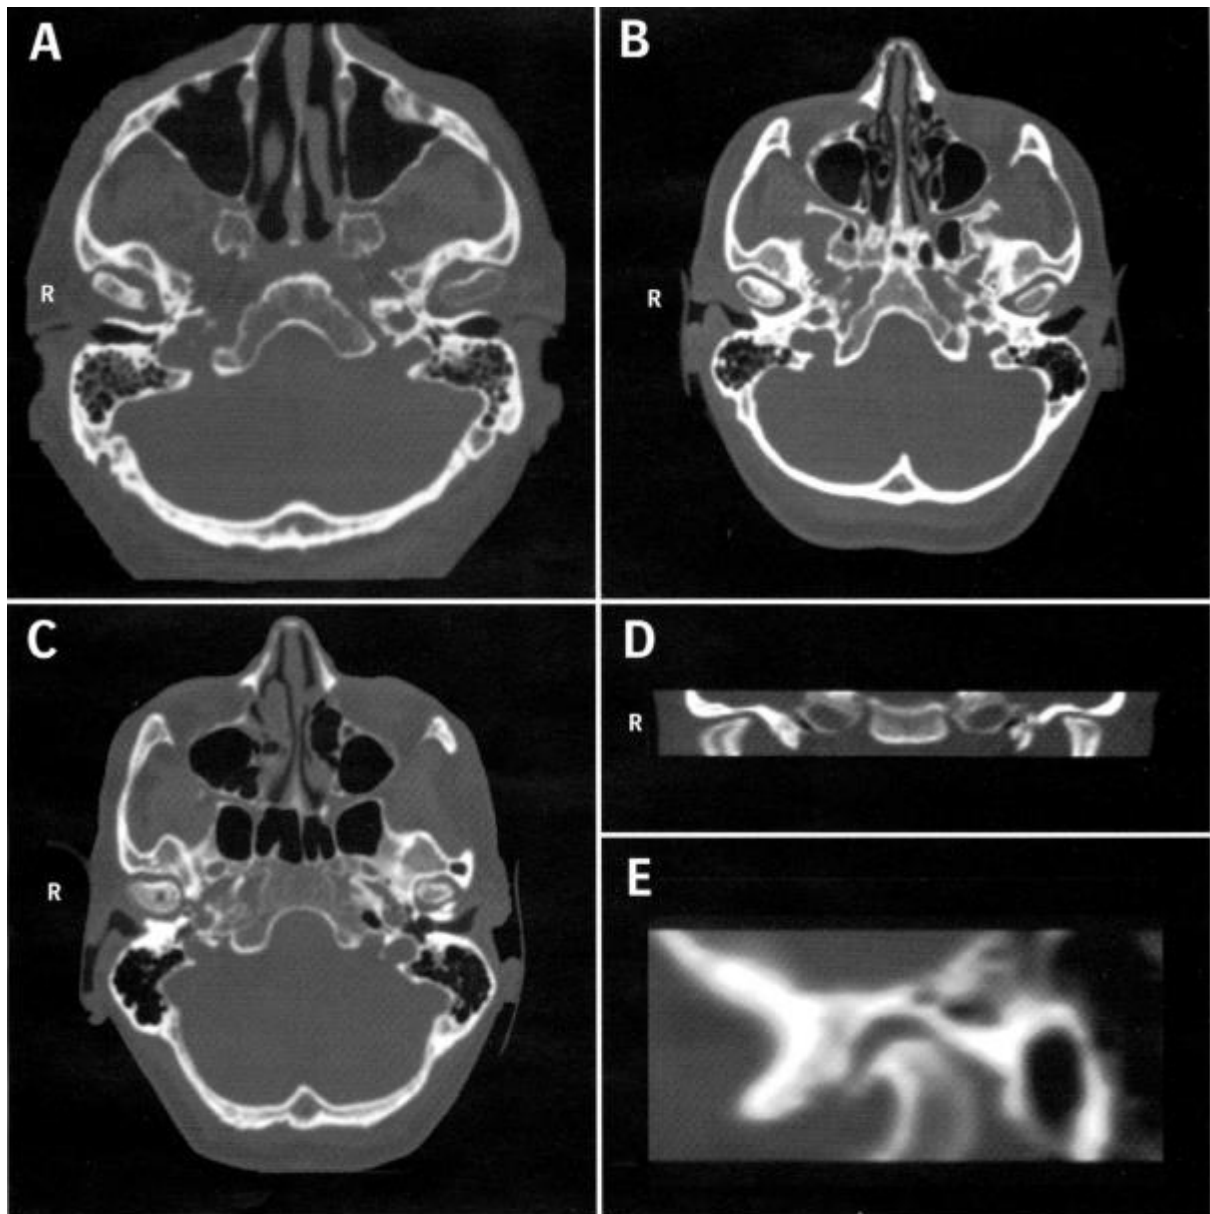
A. Sign of erosion in the medial part of the right mandibular condyle in an axial view of computed tomography. B. Sign of sclerosis in the medial and central parts of the right mandibular condyle in an axial view of computed tomography. C. Sign of pseudocyst in the central part of the right mandibular condyle on an axial view of the computed tomography. D. Sign of flattening of the right mandibular condyle in a coronal view of computed tomography. E. Sign of osteophyte in the right mandibular condyle in a sagittal view of computed tomography (Voog *et al.*, 2003).
